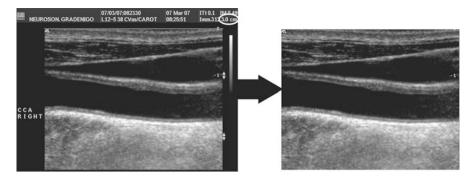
Automated cropping of the ultrasound DICOM image. The original image frame (*left*) is cropped (*right*). The *white circle* indicates the scanning depth, which could be used for manual computation of the calibration factor
